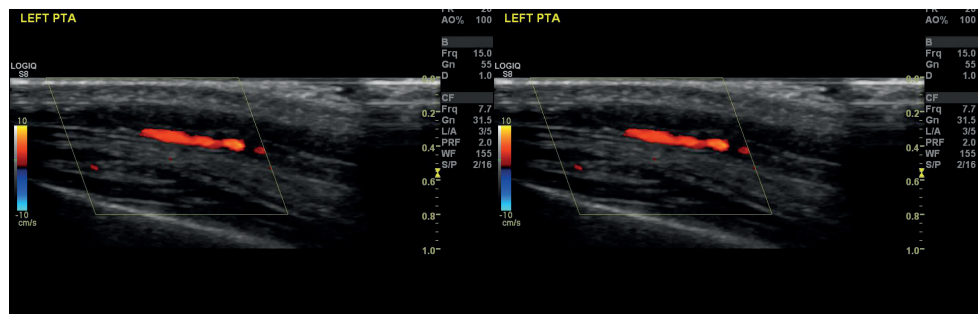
Ultrasound Doppler temporal artery showing halo sign confirming diagnosis of giant cell arteritis.
